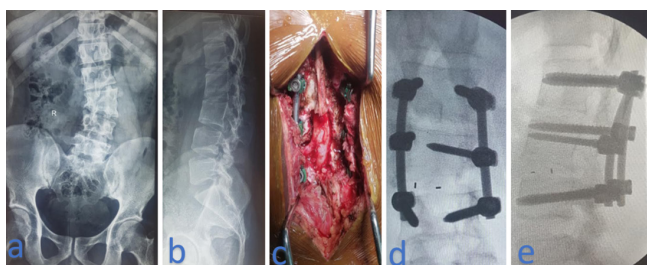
Imaging and intraoperative views of a lumbar scoliosis patient with tractional neuropraxia: preoperative radiographs (a–b), intraoperative photograph (c), and postoperative fluoroscopic AP (d) and lateral (e) views.
